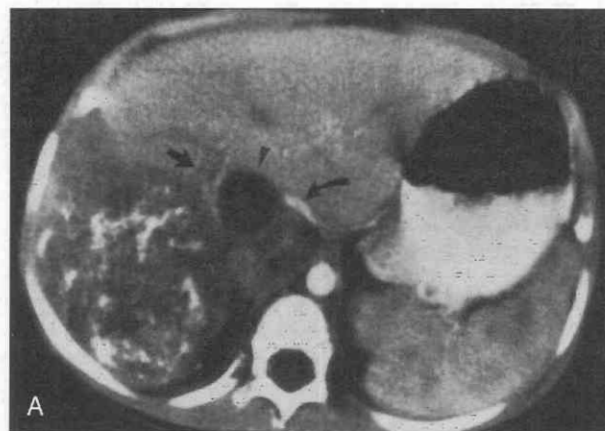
Hepatoblastoma, mixed type. *A*, Dynamic contrast-enhanced CT scan shows a large mass of the right hepatic lobe of predominantly low attenuation and containing multiple calcifications. Right portal vein invasion (*straight arrow*) and a cystic area of necrosis (*arrowhead*) are present. The inferior vena cava (*curved arrow*) is compressed by a portion of the mass. *B*, T1-weighted image shows the mass to be of predominantly hypointense signal with areas of increased signal intensity that represent hemorrhage (*arrows*). *C*, T2-weighted image shows the lesion to have increased signal intensity with hypointense bands that represent fibrous septations.
